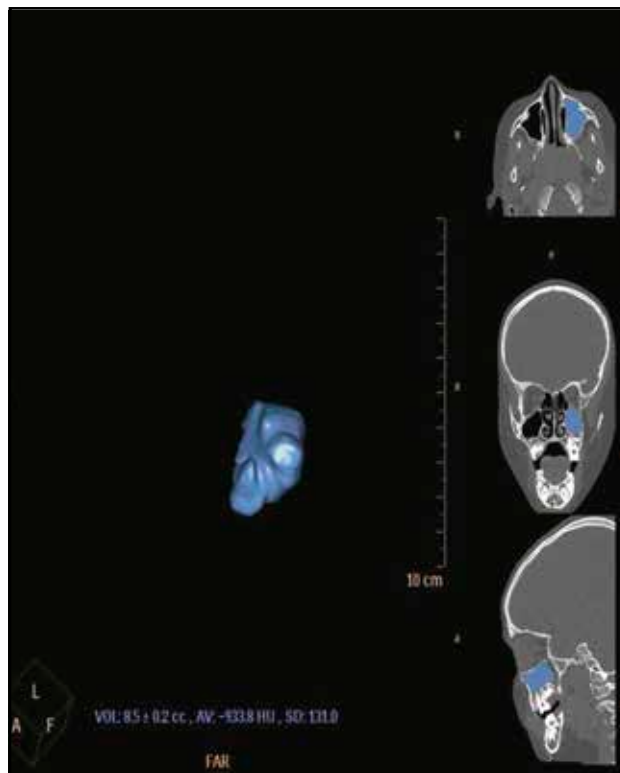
Three-dimensional (axial, coronal and sagittal planes) CT reconstruction images of maxillary sinus volume in a 10-year-old boy.
